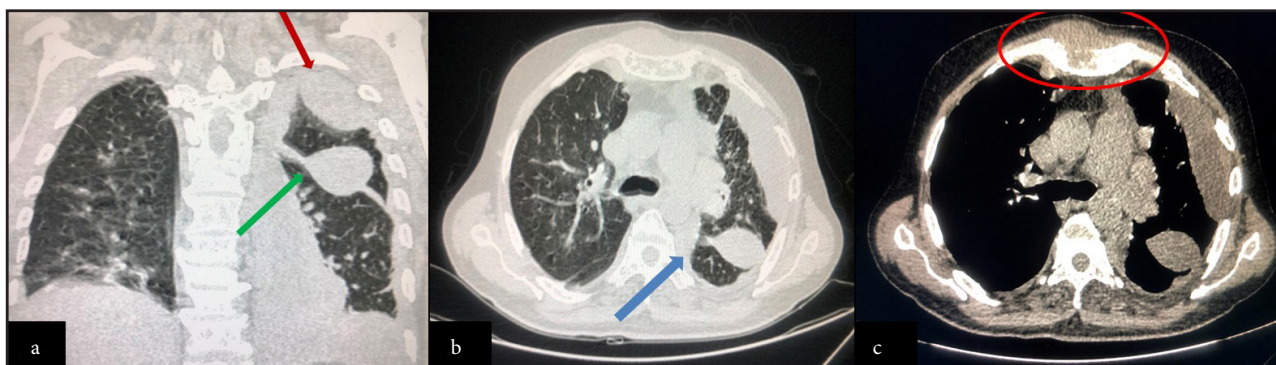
CT chest images showing (a) loculated pleural effusion (green arrow) with fissural effusion (red arrow), (b) with collapse consolidation of underlying lung on the left side (blue arrow). (c) Multiple lytic lesions can be seen in the visualized bones and soft tissue component of the plasmacytoma on the sternum and left first rib (red circle). CT: Computed tomography.
